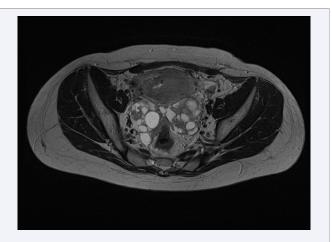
MRI of pelvic organs with intravenous contrast.
